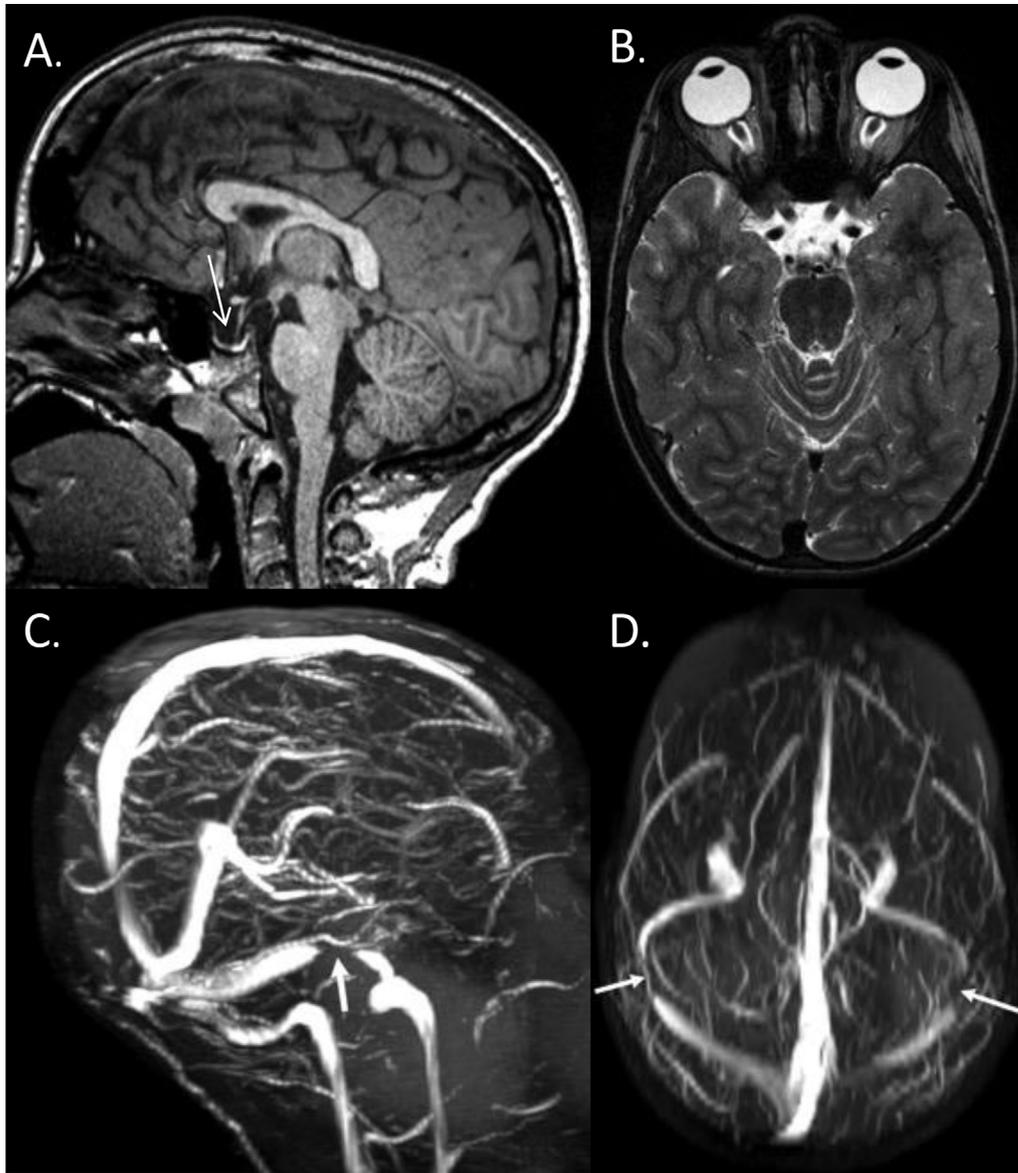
MRI features of raised intracranial pressure. (A) Sagittal T1-weighted MRI shows empty sella (arrow). (B) Axial T2-weighted MRI shows flattening of the posterior sclera, papilledema, and prominence of the perioptic subarachnoid space surrounding the optic nerve bilaterally. (C) Magnetic resonance venogram demonstrating stenosis of the right transverse sinus (arrow). (D) Magnetic resonance venogram in axial reconstruction demonstrating bilateral stenoses of the transverse sinuses (arrows). MRI, magnetic resonance imaging.
